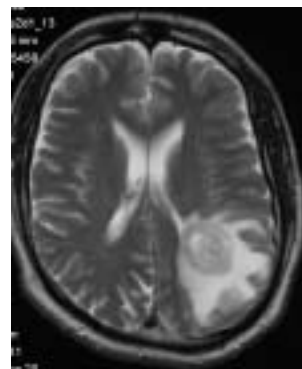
Axial T2-weighted MR image showing cerebral edema in a patient with GBM.
